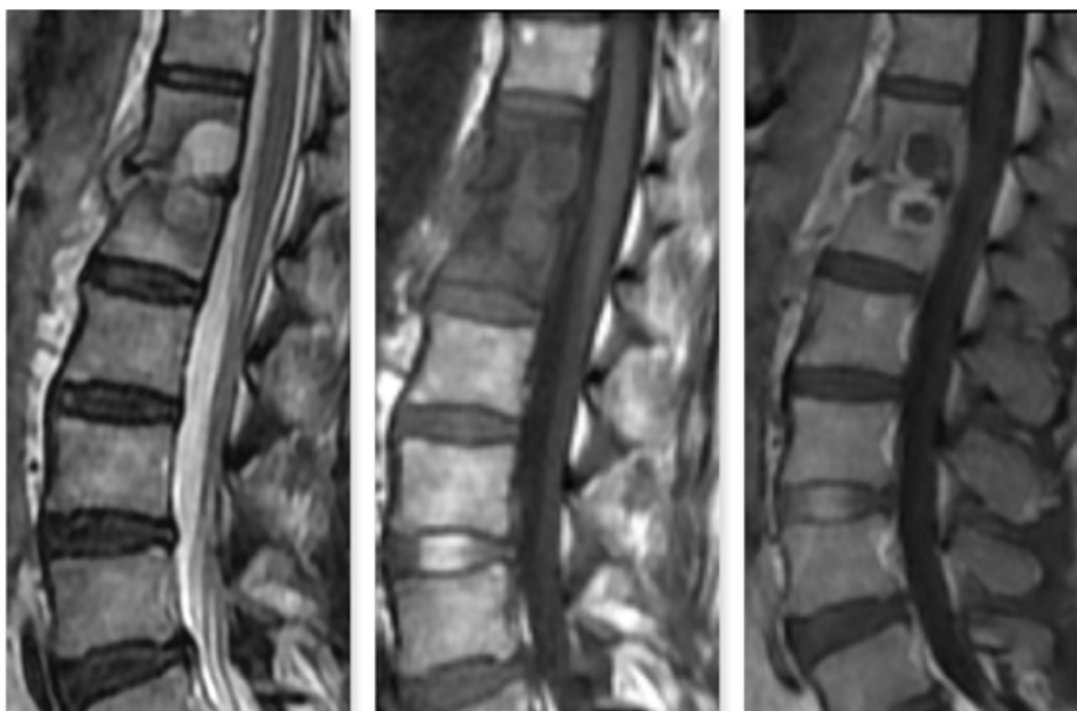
Recurrent vertebral MRI before treatment
